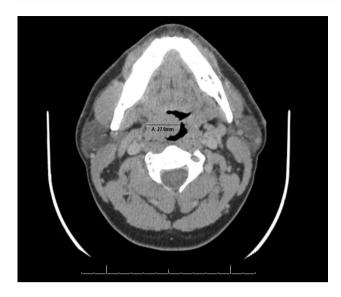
A CT scan showed non-specific enlargement of the right palatine tonsil up to 2.8 cm in diameter. The oropharynx and neck were otherwise unremarkable
